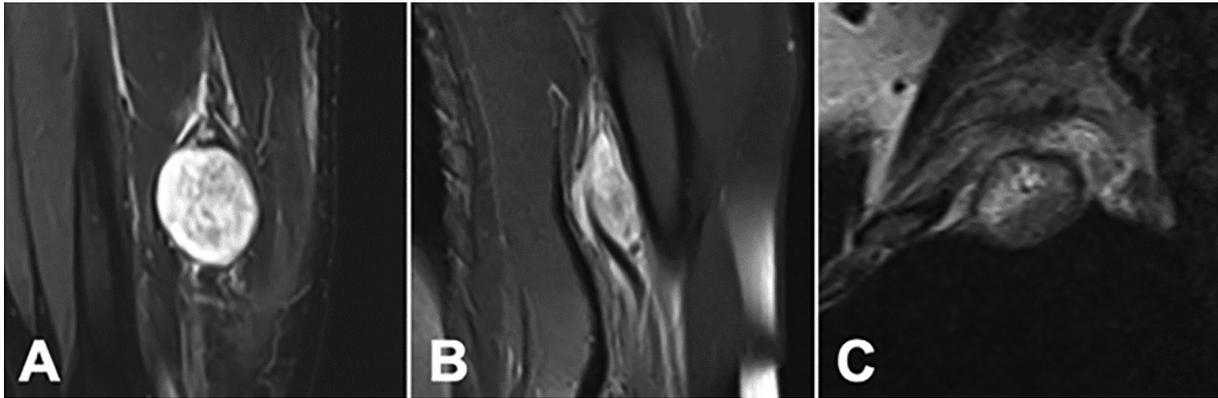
Indistinct features of benign and malignant peripheral nerve tumors on contrast enhanced MRI: (A) tibial nerve Schwannoma in the proximal part of the lower leg; (B) median nerve MPNST in the forearm; and (C) brachial plexus MPNST as seen on MRI without contrast. Note the homogenous structure and similar contrast enhancement of both benign and malignant PNTs.
